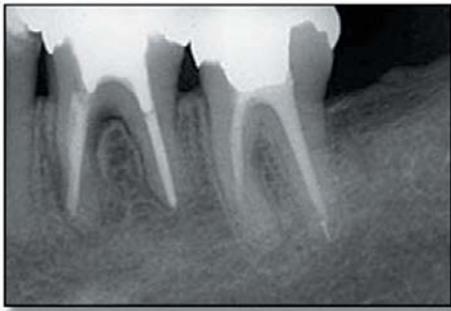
Radiograph at 48 months. Note the obvious bone fill in the furcation area and absence of a radiolucent area.
